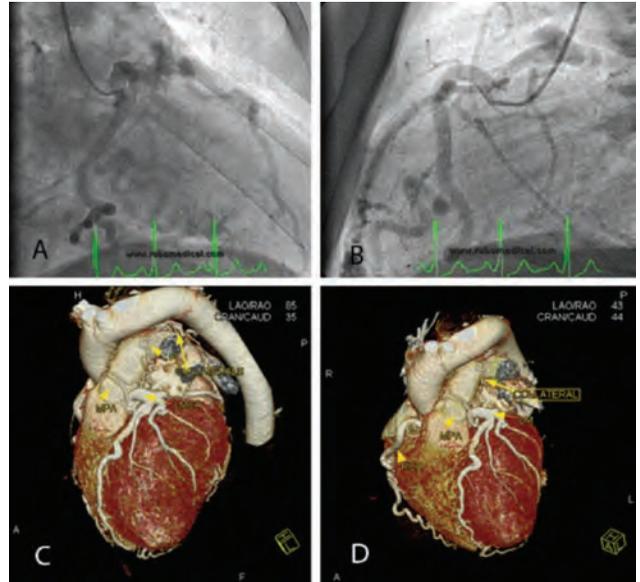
A-B view of right coronary artery during angiography, C-D view of collaterals in CT angiography.
